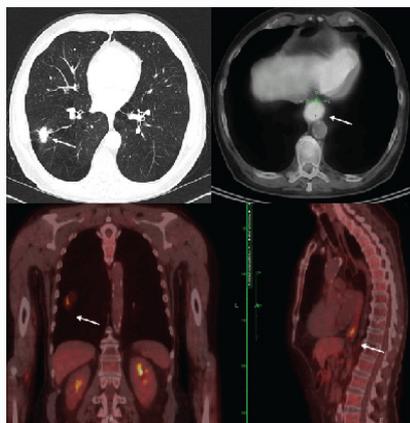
Axial image from preoperative chest Computerized Tomography (CT) scan (upper left panel) and axial (upper right panel), coronal (lower left panel), and sagittal (lower right panel) images from preoperative Positron-Emission Tomography (PET)-CT scan showing the right lung mass (upper and lower left panels) and the esophageal mass (upper and lower right panels).
